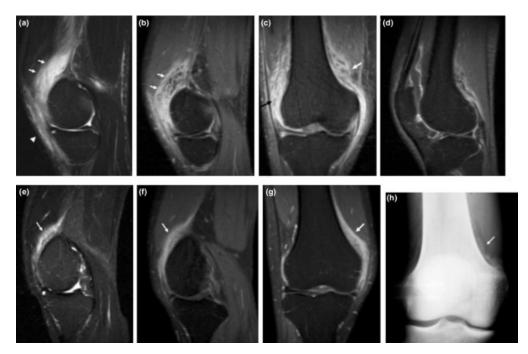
MRI Findings of Early and Maturing HO in the right knee of a 35-Year-Old Male with TBI.
